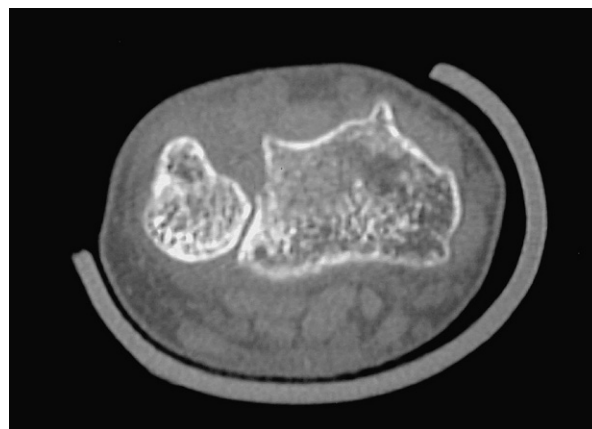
Preoperative CT scan showing reduced ulnar head with depressed fracture of dorsal lip of sigmoid notch.
